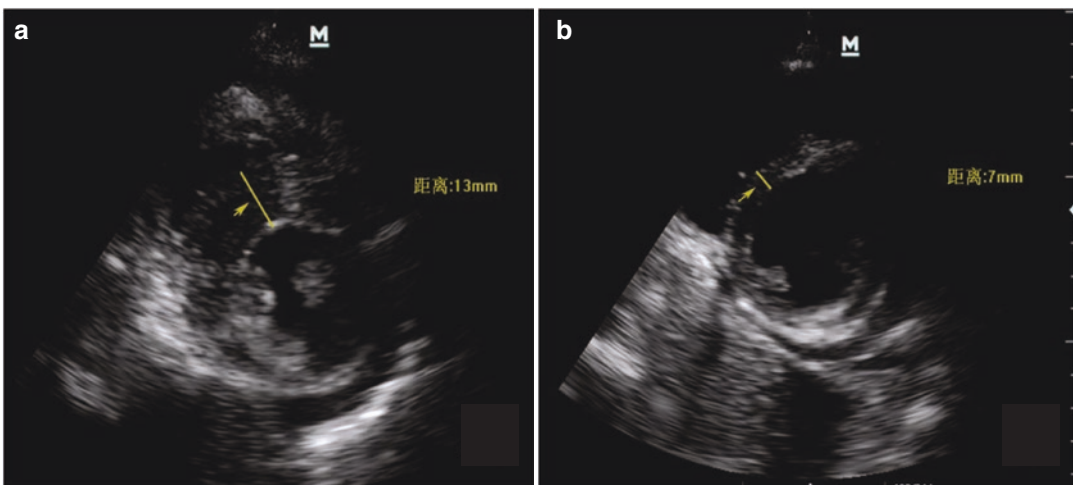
Echocardiographic short axis views in a patient with FM. (a) Thickened interventricular septum during hospitalization (13 mm, yellow arrow); (b) Thickened septum normalized at 1 month follow-up (7 mm, yellow arrow)
